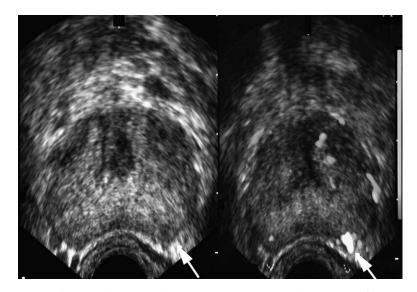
(*Left*) Conventional gray-scale TRUS of prostate. The *solid arrow* points to area of prostate cancer. (*Right*) Doppler Color ultrasound shows significant hypervascularity of this area as indicated by the *solid arrow*. Assessment of extracapsular extension is difficult. Directed biopsy of this region showed intermediate grade adenocarcinoma.
